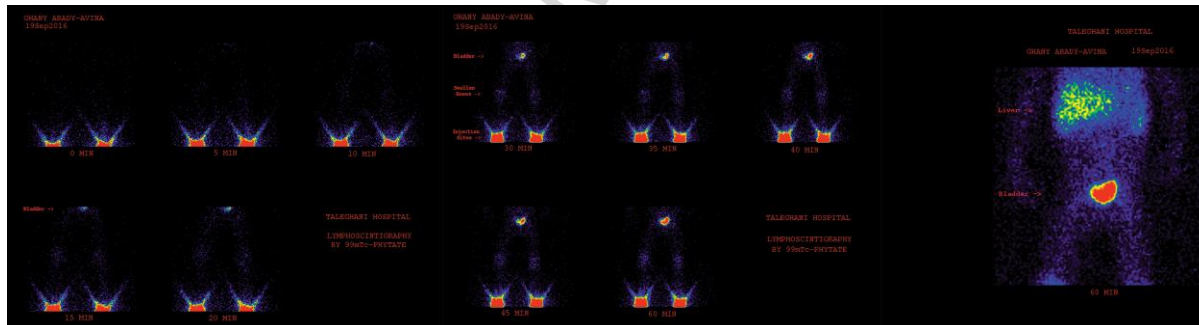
Picture of lymphoscintigraphy.
